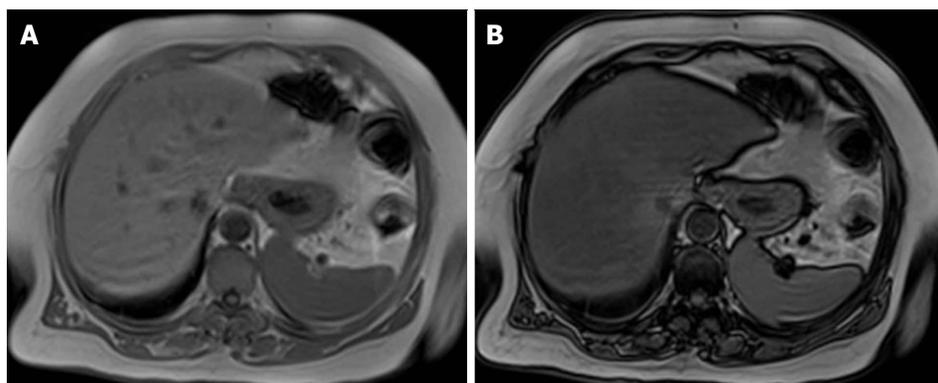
Magnetic resonance imaging evaluation of fatty liver using chemical shift imaging. A: In-phase image; B: Out-of-phase image. When out-of-phase image is compared with in-phase images, it shows the signal intensity decrease.
